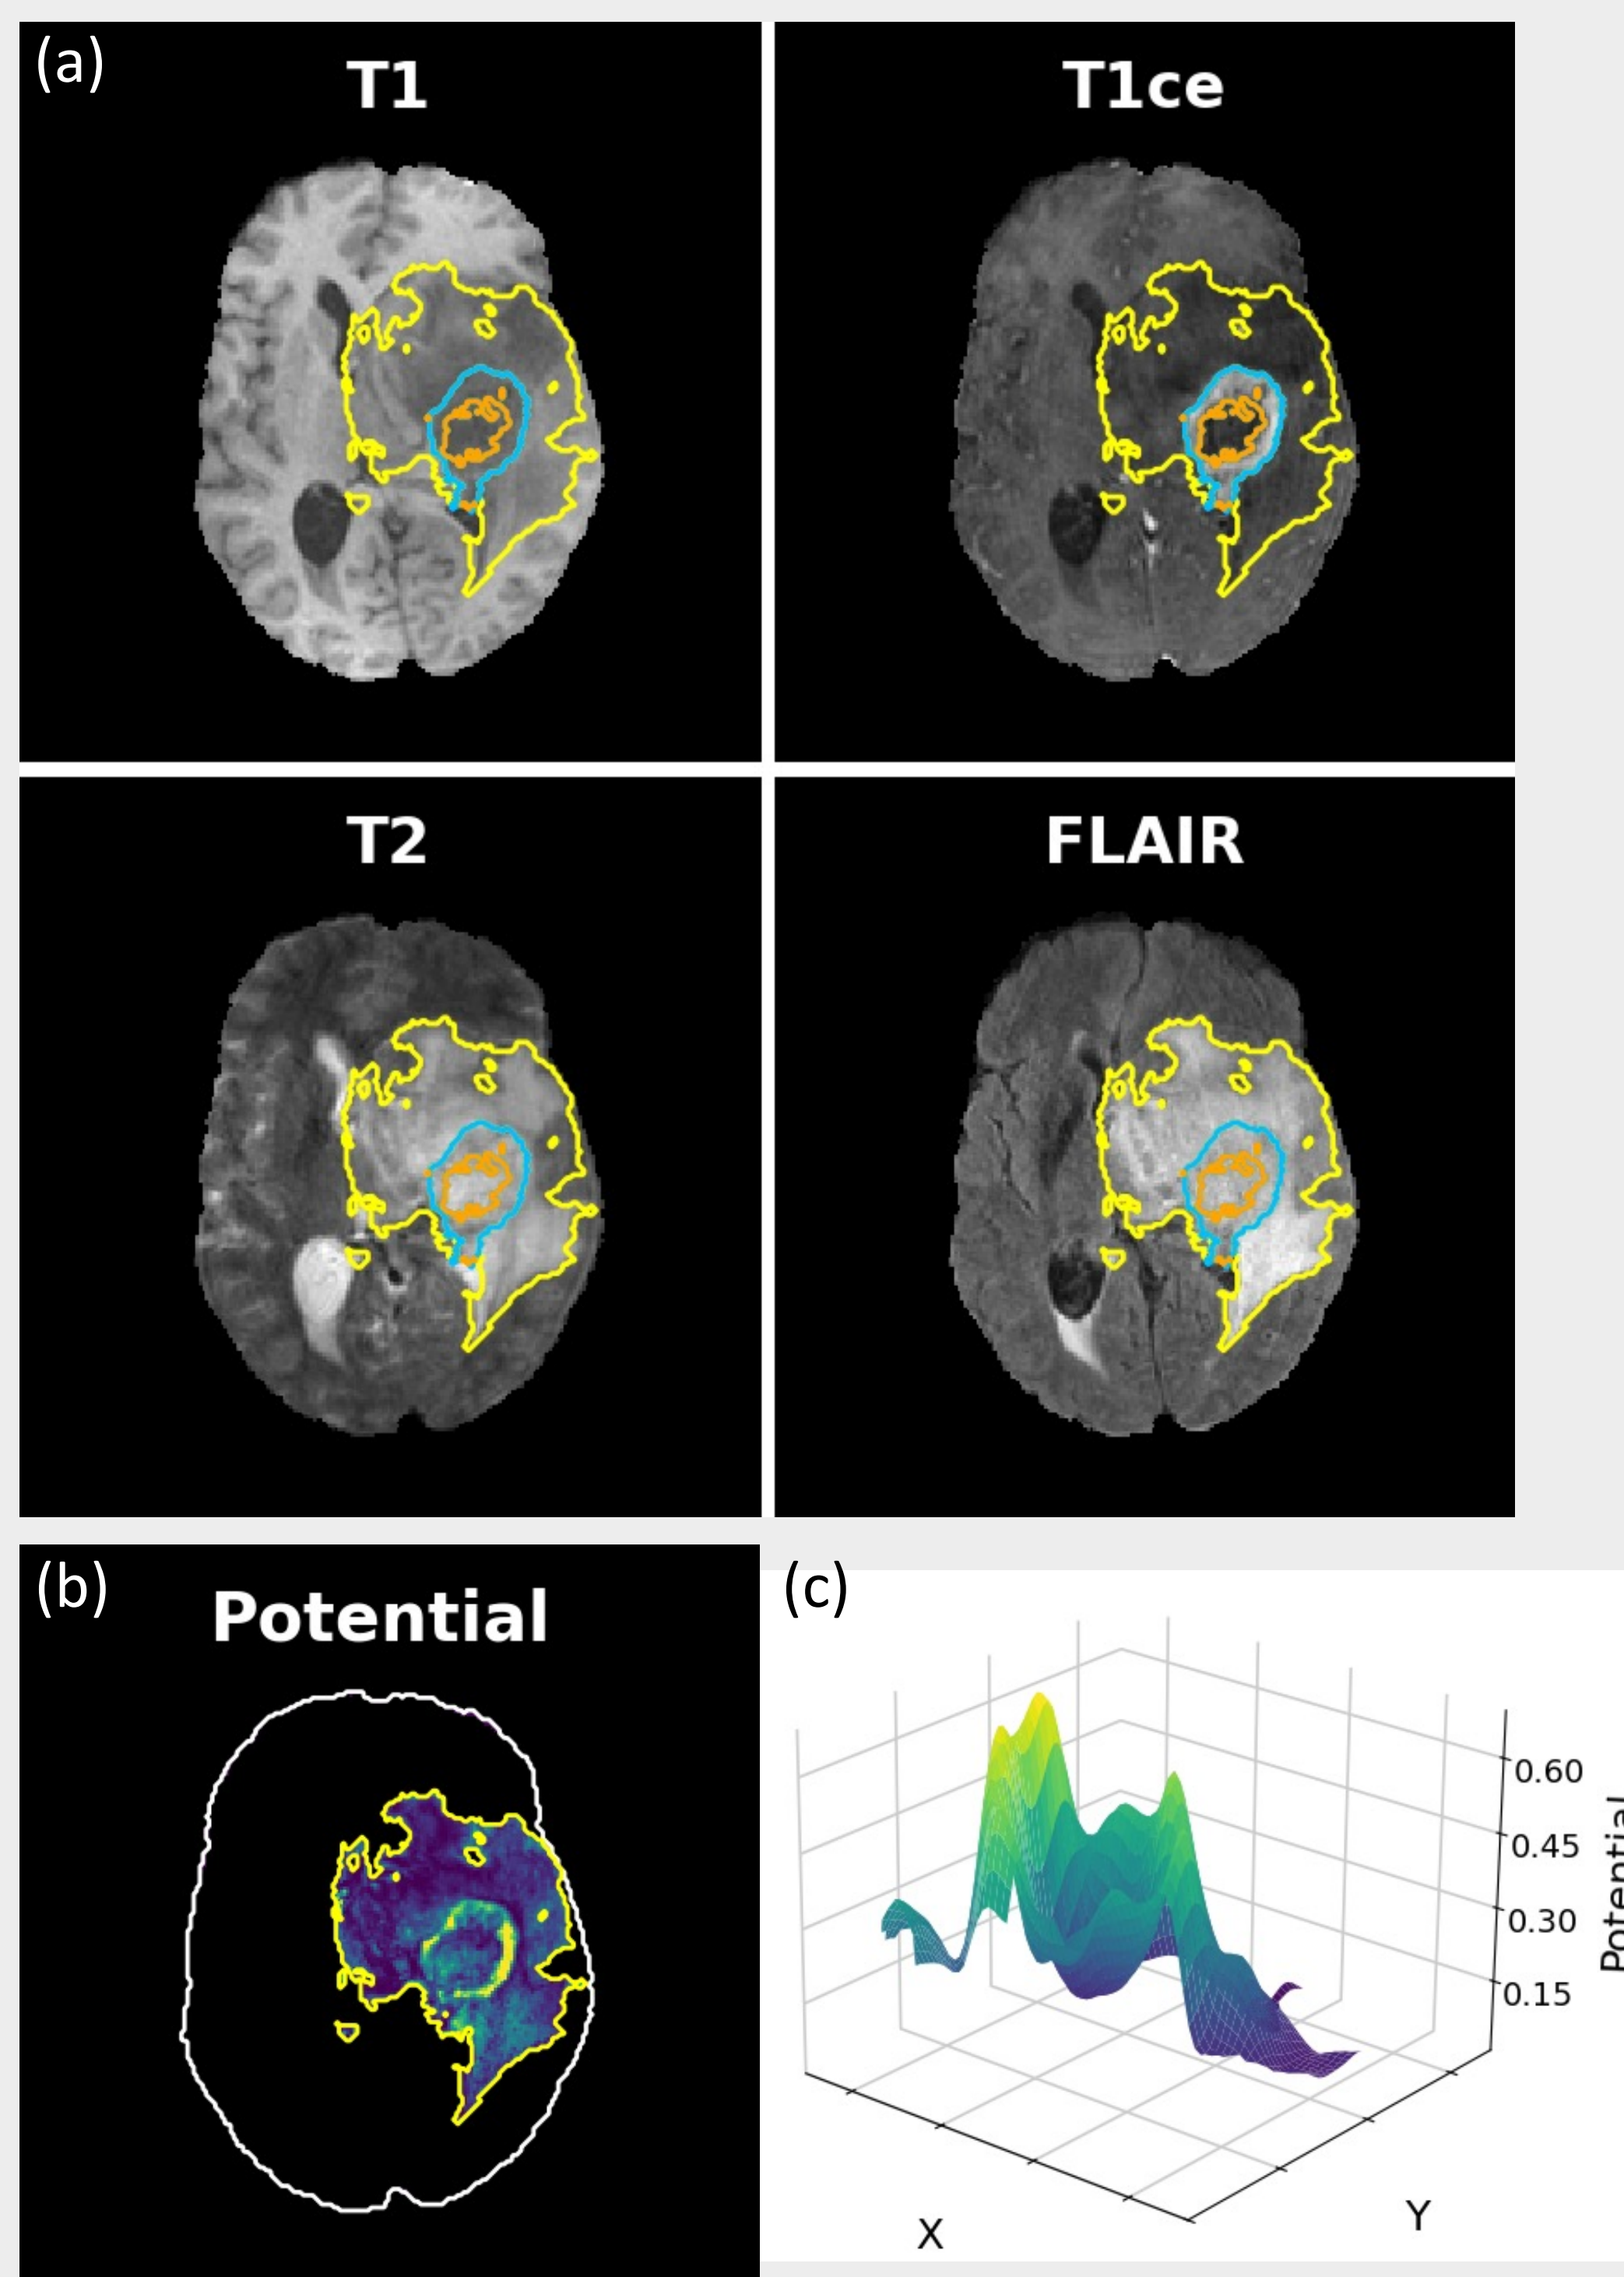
Representative case of mpMRI images and the derived potential field. (a) Axial views of T1, T1ce, T2, and FLAIR with contours of the necrotic core (orange), enhancing tumor (blue), and peritumoral edema (yellow). (b) Derived potential field on the same axial slice within the ROI. (c) 3D surface rendering of the same potential field.
